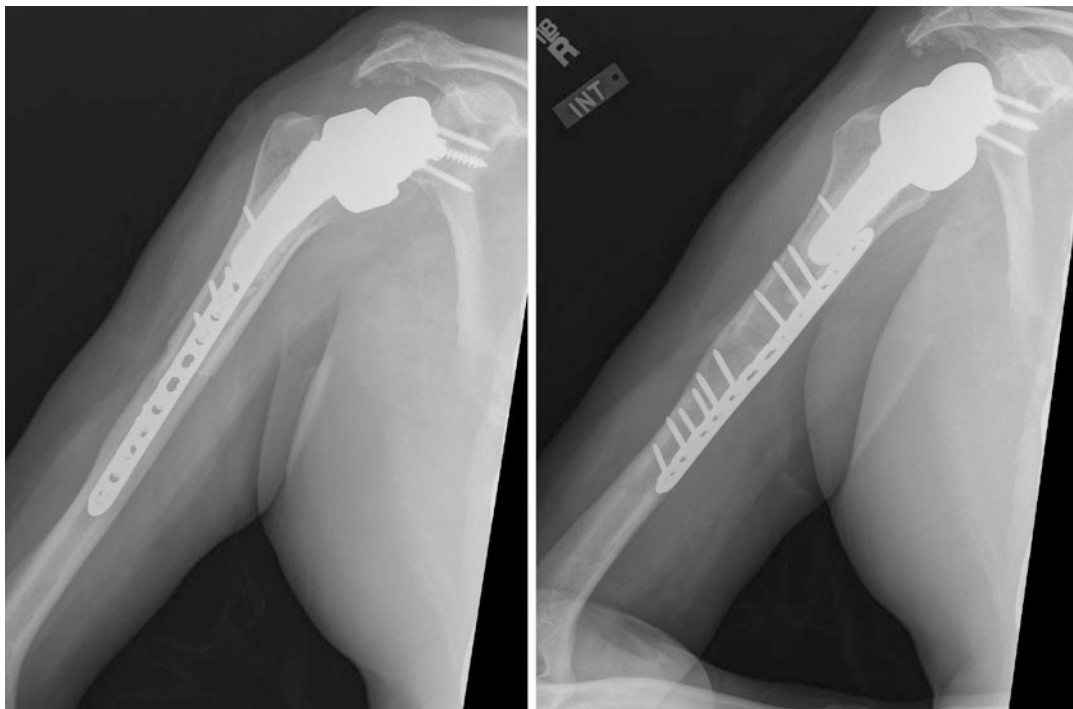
Two-year postoperative anteroposterior and lateral radiographs of a 69-year-old male treated with a reverse shoulder arthroplasty with an APC
